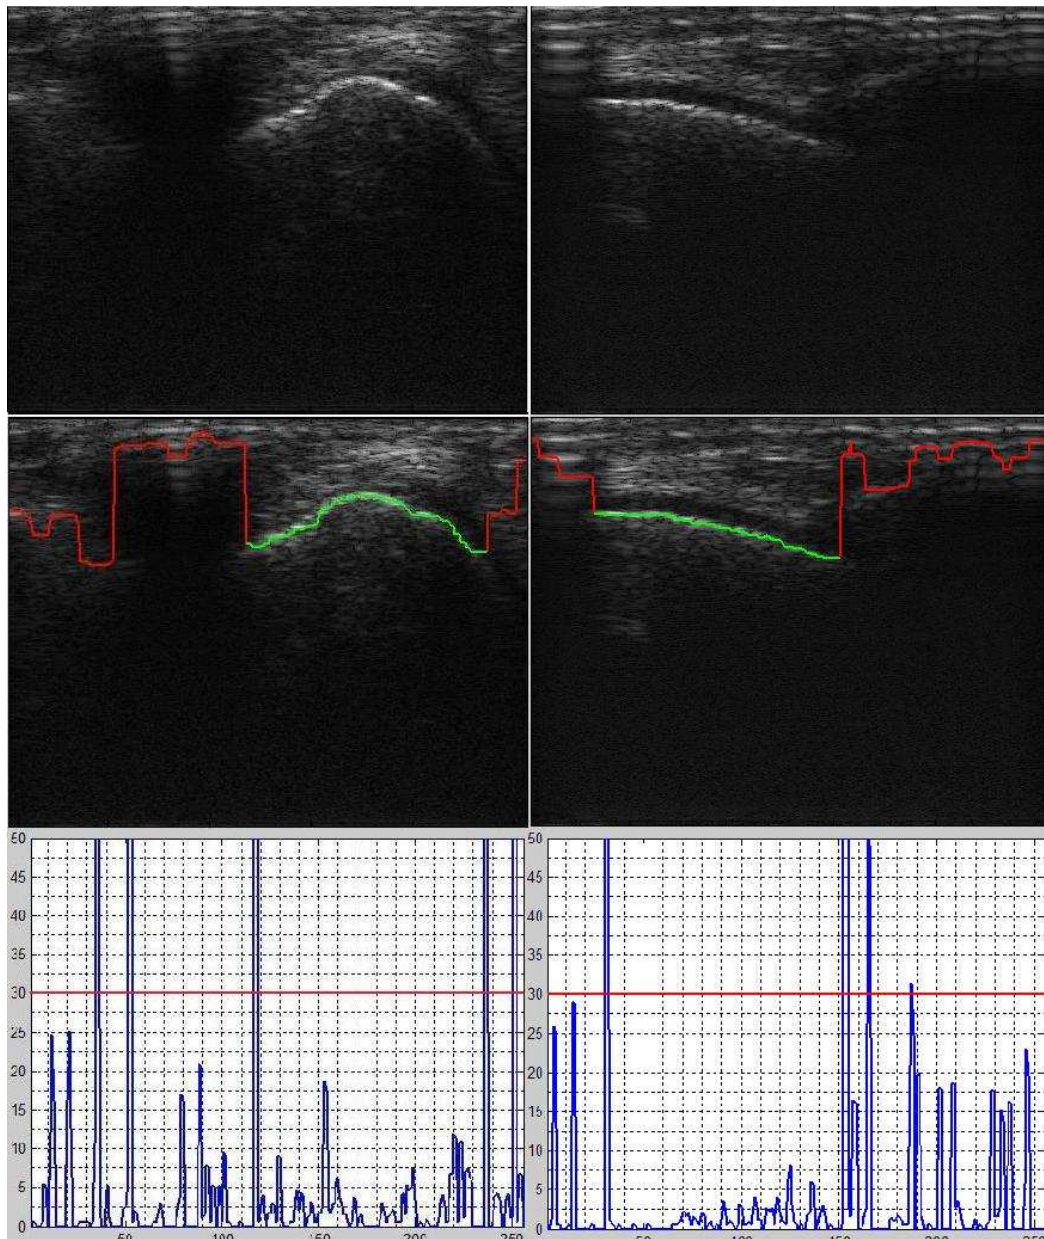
Sample ultrasound B-mode images (top) for frames with partial bone contour segments, showing the extracted contour from their RF data overlaid on the B-mode images (middle), and the contour's local standard deviation with the threshold line (bottom). The true bone contour segments are shown in green, while the filtered out noise contour segments are shown in red
